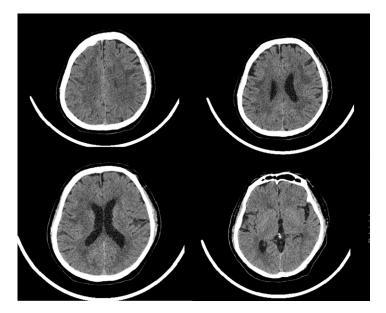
Computed tomography of the head before admission: Computed tomography examination revealed multiple small patchy hypodense areas in the brain.
